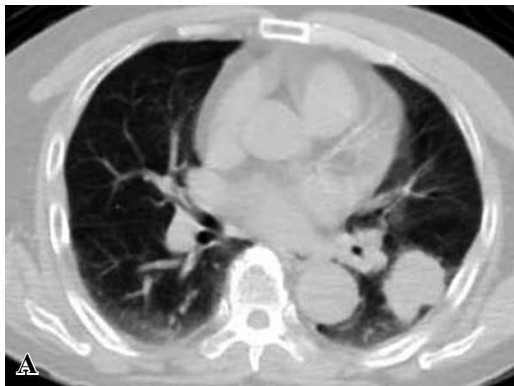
Chest CT showing a mass lesion measuring 38×31mm in the lower lobe of the left lung (A), FDG-PET showing accumulation in the lung tumor and a hilar lymph node (B).
